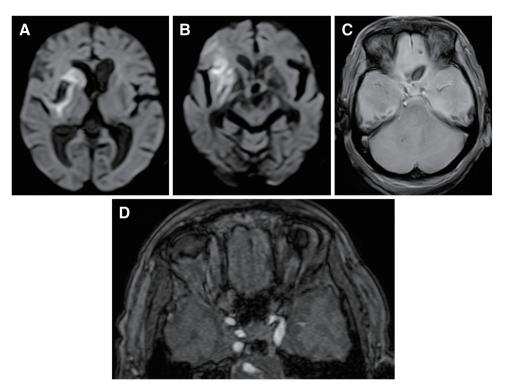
Head MRI on the day after thrombectomy (A–D). Diffusion-weighted images show high intensity of the basal ganglia and frontal lobe, with an intact oculomotor nucleus (A and B). T2*WI shows no hematoma and nothing compressing the oculomotor nerve (C). MRA shows no findings indicating an arteriovenous fistula, including hyperintensity in the cavernous or intracavernous sinus and in the superior ophthalmic vein (D). T2*WI: T2* weighted image
